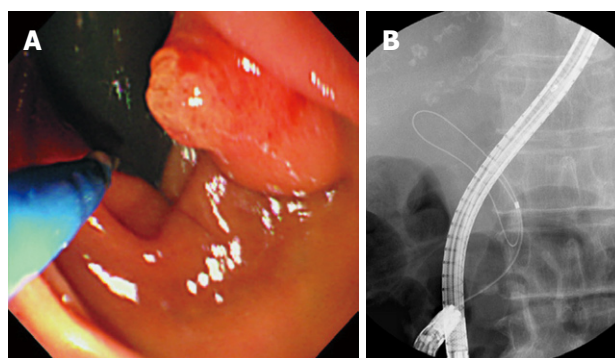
Selective biliary cannulation conducted with a thin forward-viewing endoscope. A: Endoscopic view showing endoscopic retrograde cholangiopancreatography (ERCP) catheter approaching to the papilla; B: X-ray picture showing common bile duct cannulation conducted with wire-guided technique without contrast injection.
